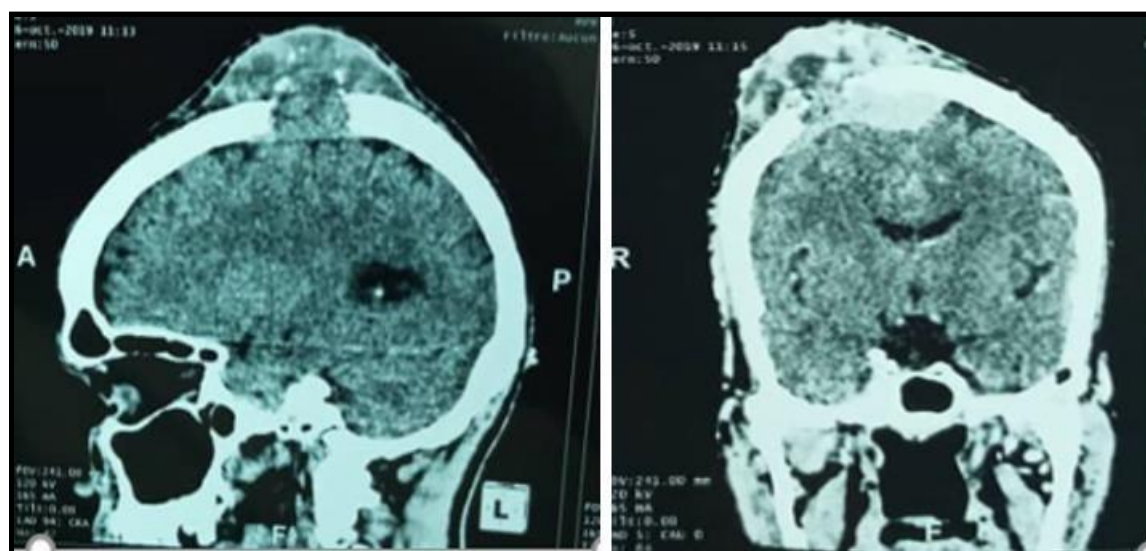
Cerebral CT scan in a parachymal window, sagittal (A) and coronal (B) reconstruction: right fronto-parietal craniocerebral tumour mass taking up the PDC with exocranial extension and bone lysis.
